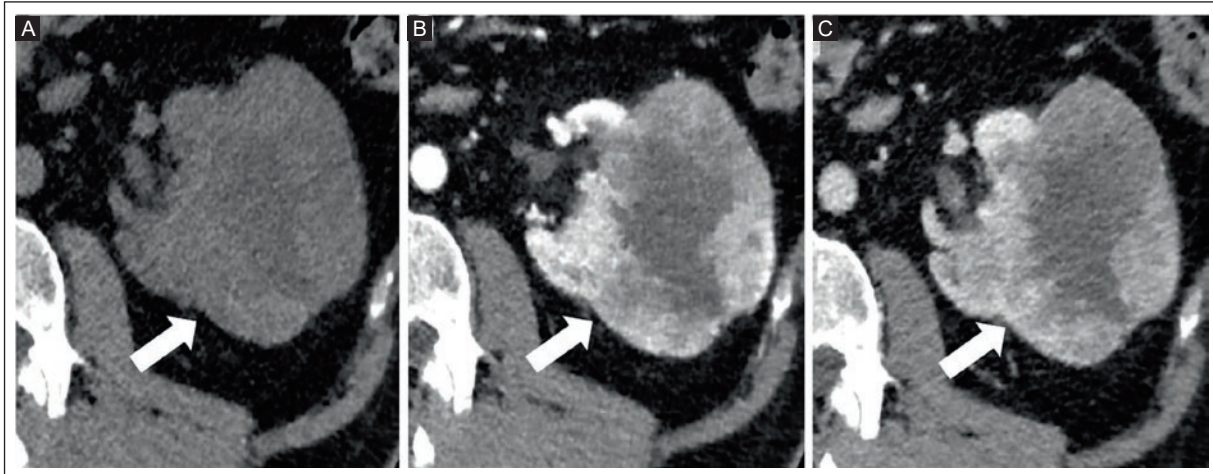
CT of a 53-year-old man with a left-kidney lesion diagnosed as ccRCC. A: hypodense lesion with a necrotic central part on non-contrast CT (arrow). B: arterial phase, and C: nephrographic phase, show strong and heterogeneous enhancement (arrows).
